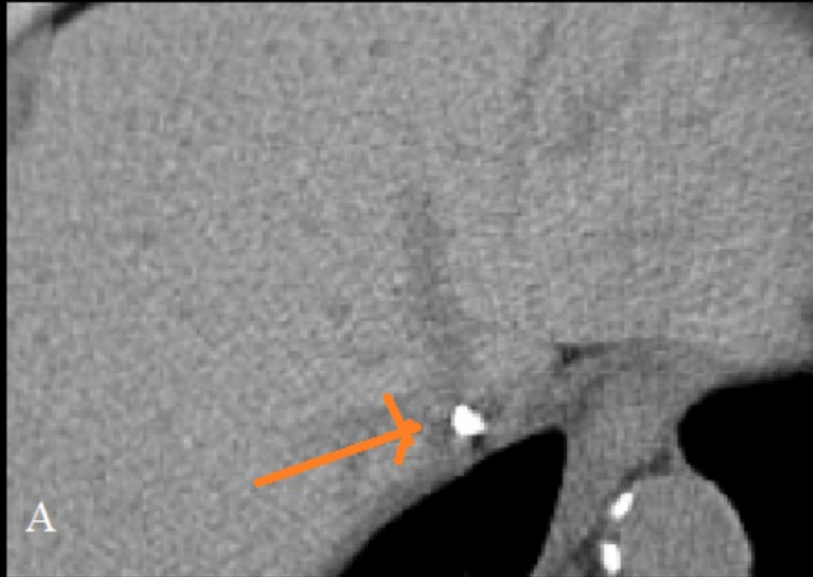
Dialysis catheter in the IVC: Unenhanced axial and coronal computed tomography reformations show a dialysis catheter in the IVC (red arrow).
